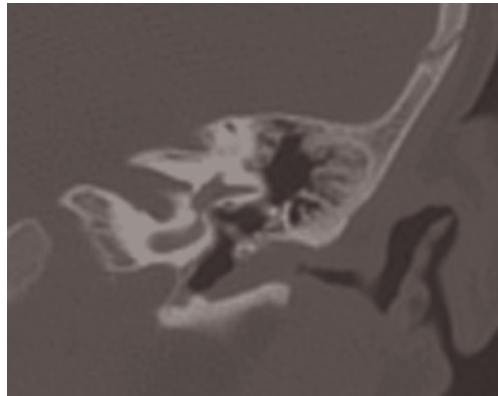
Coronal CT scan. Stenosis of the left external auditory canal, involving the soft tissue only.
